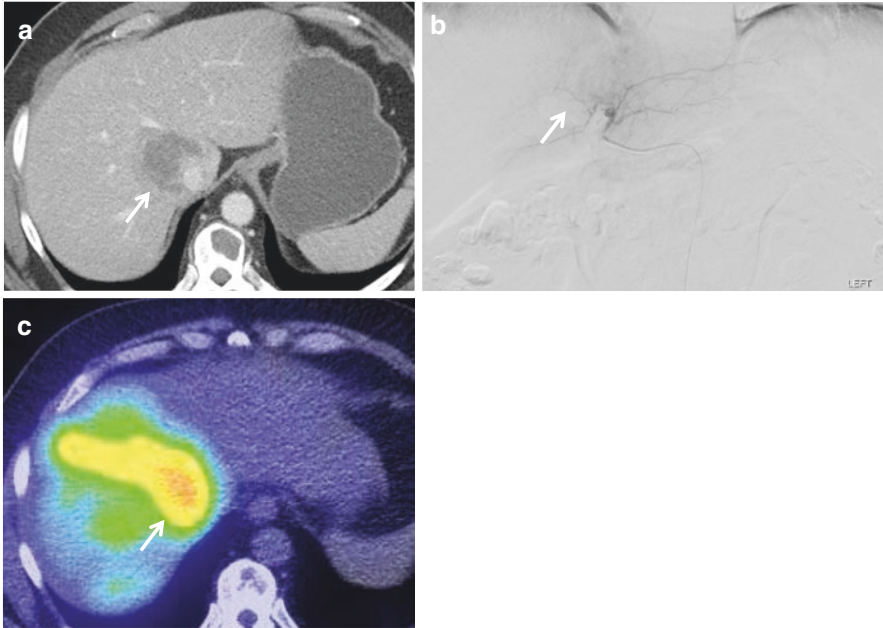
Large mass-forming intrahepatic CCA with hepatic vein invasion evaluated with CT and catheter angiography and treated with transarterial radioembolization (TARE). The mass in the central superior right hepatic lobe shows (a) minimal central enhancement on contrast-enhanced CT (white arrow) and (b) mild enhancement on selective right hepatic arteriogram (white arrow). The mass was treated with yttrium-90 (Y90) transarterial radioembolization (TARE). (c) Post-Y90 SPECT/CT bremsstrahlung scan shows intense uptake within the tumor corresponding with the region of treated tumor. SPECT single-photon emission computed tomography, CT computed tomography
